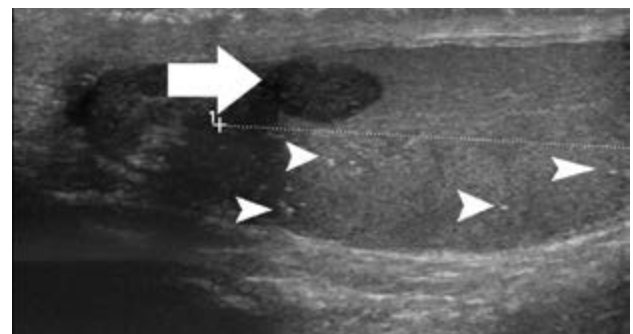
Seminoma of the left testis and findings of classic grade I microlithiasis in a 32 - year old man. Scrotal ultrasound; longitudinal section of the left testis and ipsilateral epididymis. The neoplasm emerges as a mainly homogeneous hypoechoic lesion (arrow) in the upper pole of the testis. Coexisting findings of classic grade I microlithiasis (arrowhead)
